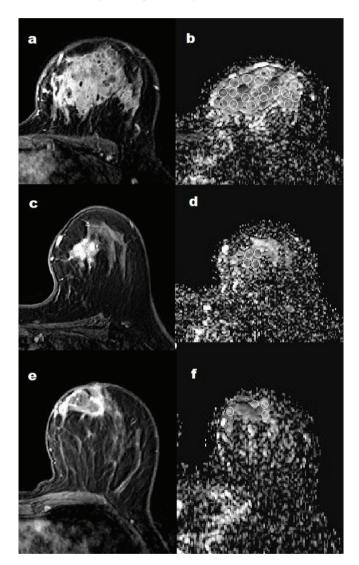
(a, b) The DCE-MR image of a 20-year-old patient with a diagnosis of IGM shows a large area of NME and microabscesses in the left breast. A low signal intensity was measured in this area on the ADC map. (c, d) A 36-year-old patient with a diagnosis of IGM has an enhancing mass lesion in the left breast on DCE-MR image. ADC values were measured from the mass on the ADC map. (e, f) A 42-year-old patient with IGM had a central non-enhancing abscess in the left breast. A low signal intensity is noted in the central part on the ADC map, while a higher signal intensity is visualized on the enhancing wall. ADC measurement was taken from the wall
